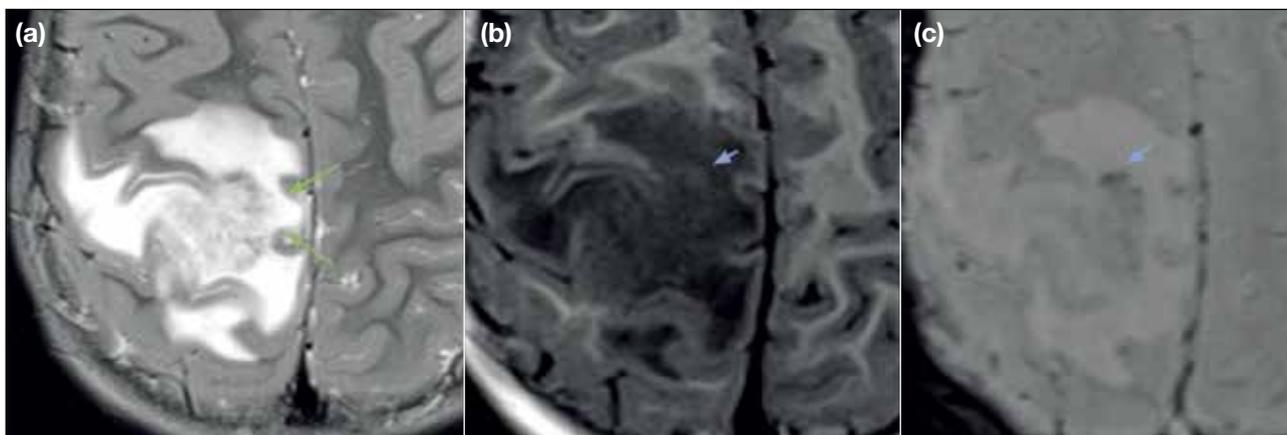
Close-up magnified views of the selected magnetic resonance imaging sequences highlight characteristic features of (a) finger-like extensions (or known as intracavitary projections) as seen as the fluffy borders on T2-weighted images (green arrows), and (b, c) paramagnetic elements (commonly melanin production) as seen as susceptibility artifacts and/or hyperintensities on T1-weighted images (short blue arrows).
